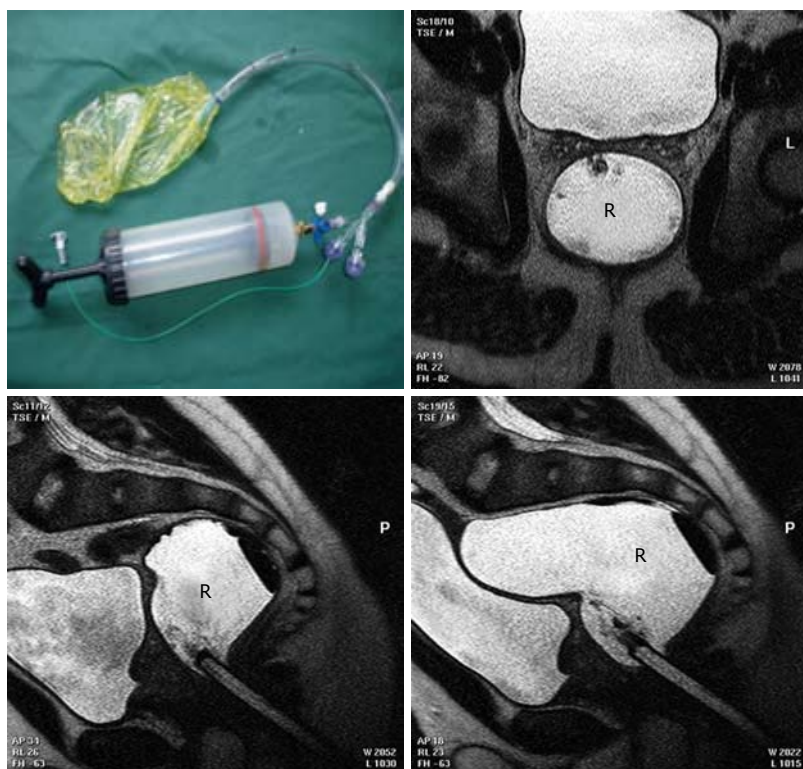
Stepwise distension of water filled balloon with simultaneous MRI and pressure recording. The rectal probe (upper left) allows rectal water distension and pressure measurement. MRI shows the distended water-filled bag in the rectum (R). The sagittal MRI (lower panel) shows the distension, elongation and relation to neighbouring structures at 100 mL and 300 mL inside the bag. Modified from [50].
